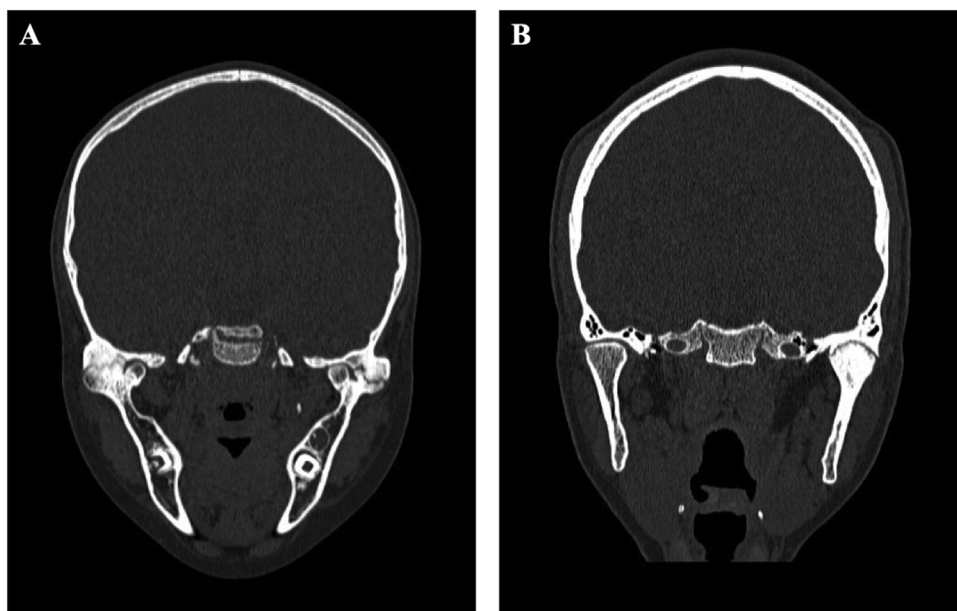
The 'C' classification. (A) C<sub>0</sub>: coronal section of a spiral CT showing bilateral lateral bony ankylosis with medially displaced condyle heads preserved. (B) C<sub>1</sub>: coronal section of a spiral CT showing left ankylosis with bony fusion without a recognizable condyle and fossa.
